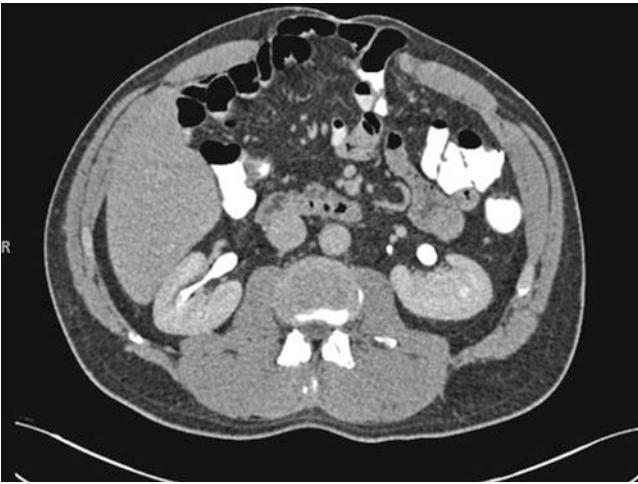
A moderate midline defect with adequate residual abdominal wall musculature. CT findings suggest success with an endoscopic component separation of the external oblique aponeurosis with a retro-rectus placement of the mesh
